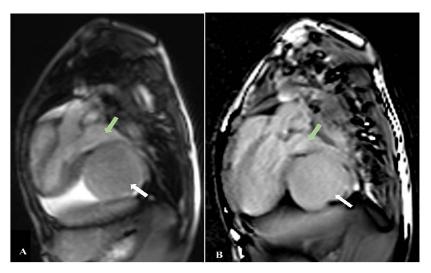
Axial section of MRI through level of IMT
